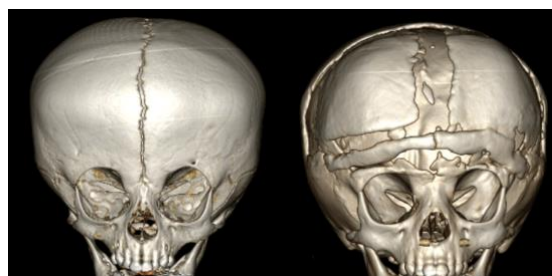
Preoperative and post operative 3D CT
